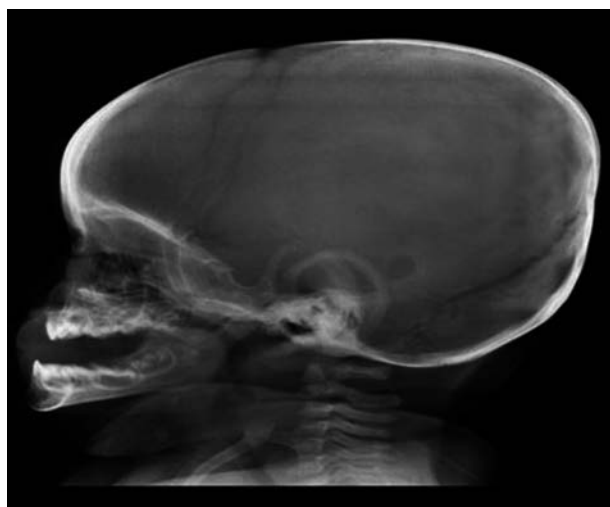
Skull X-Ray Image
